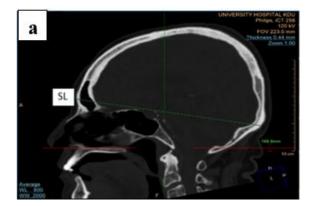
CT image showing the SL
